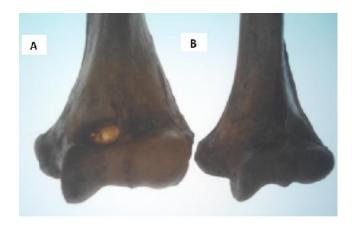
Shwoing distal end of humerus against x-ray lobby (A: Translucency septum, B: Opaque septum)
